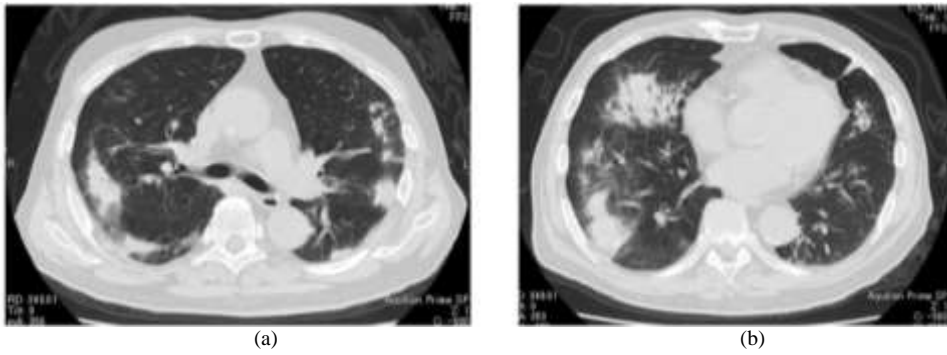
Chest CT on admission showed infiltration shadows with an air-bronchogram and ground-glass opacity in the peripheral part, dominant in both lung fields
